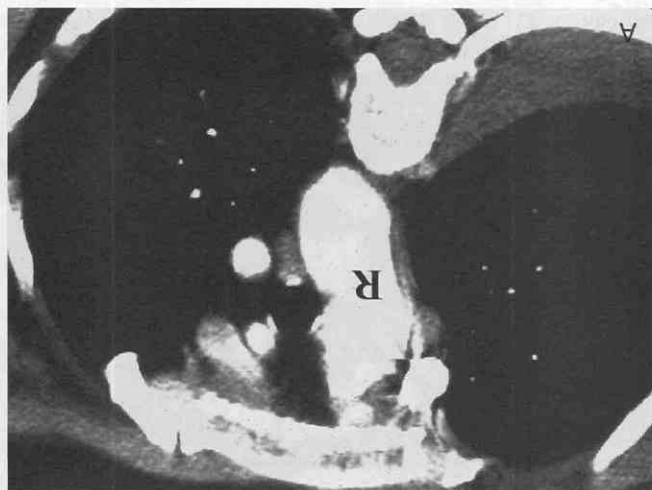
A, Axial CT scan shows a right-sided aortic arch (R). B, An axial CT scan at a level inferior to that of A shows a smaller left-sided aortic arch (L).
